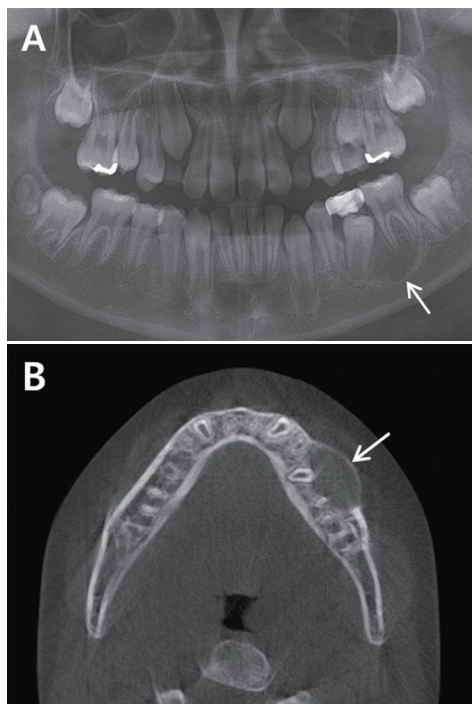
Panoramic view (A) shows a well-defined osteolytic lesion (white arrow) under the treated left deciduous molar including the tooth germ of the left second premolar and the periapical region of the first molar. the axial computed tomography (CT) view (B) shows expansion of the buccal cortical plate of the mandible (white arrow).
